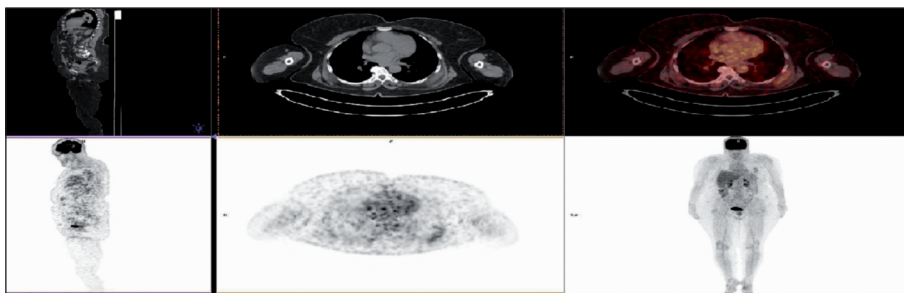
PET/CT images demonstrated increased ¹⁸F-FDG uptake (left anterior scapular muscles plans SUVmax:5.5). The mass size was 25x56 mm.
